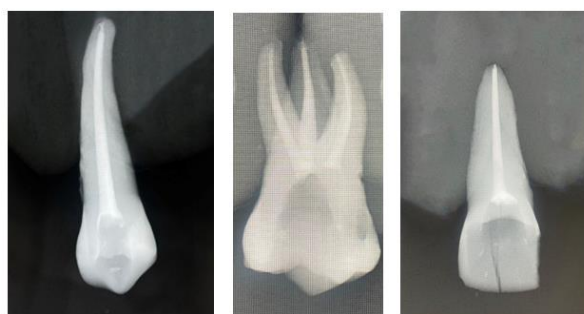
X-ray images to control the quality of obturation of root canals
